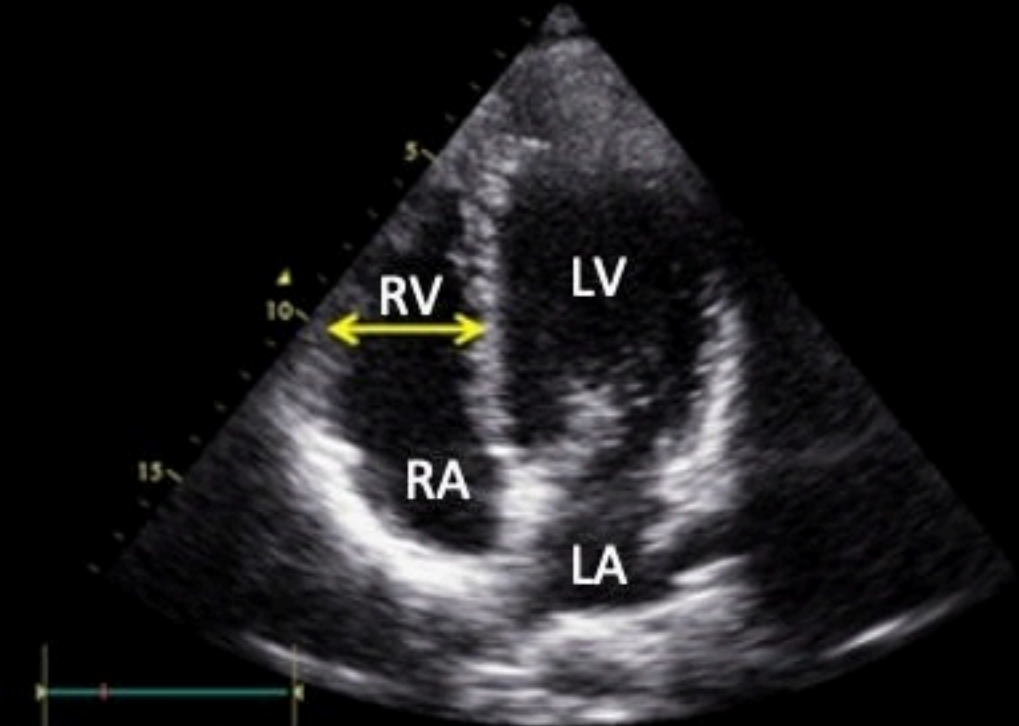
Right ventricular (RV) response to progressive chronic pressure overload. The evolving phases of RV adaptation to pressure overload could be non-invasively assessed by different echocardiographic parameters. In the early stage of homeometric RV adaptation, the use of advanced techniques could be useful to detect the subtle impairment of RV function, such as measuring free wall RV longitudinal strain by Speckle Tracking Echocardiography. Later during the homeometric RV adaptation phase, overt RV systolic dysfunction could be recognized by reduced RV fractional area change and s' wave by tissue doppler imaging. Finally, in the heterometric phase, RV structural changes and desynchronization occur, and these could be evaluated also by basic echocardiographic parameters, i.e. RV diameters, systolic pulmonary artery pressure (sPAP) and tricuspid annular plane systolic excursion.
